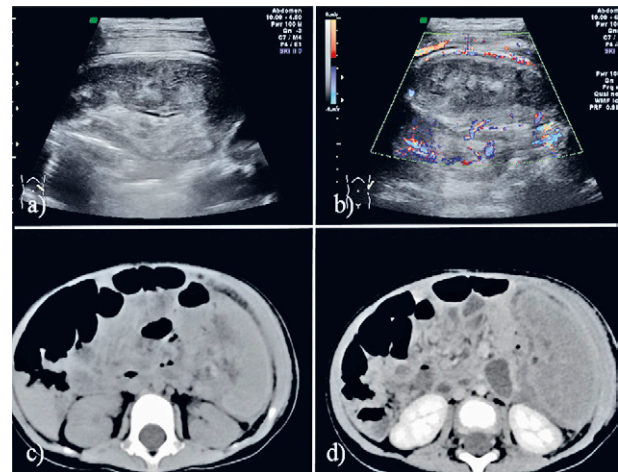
a) Gray ultrasound showed an oval, ill-defined, and inhomogeneous mass with necrotic areas within and a capsule peripherally; b) Color Doppler flow imaging showed no apparent blood flow signals were noted internally and abundant blood flow signals surrounded the mass; c) Plain computed tomography showed the mass was regular and well-defined with visible exudation surrounding it; d) Enhanced computed tomography showed the margin of the mass was mild enhancement and the central area was insignificant enhancement.
